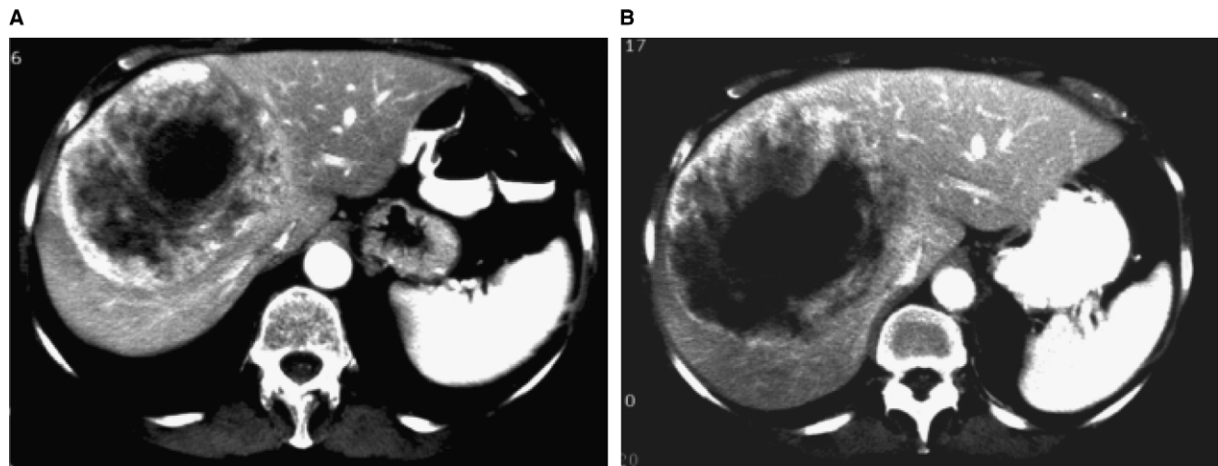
CT scan of liver metastasis from gastro-intestinal stromal tumour (GIST) in a 69-year-old woman treated with SU006668 for 28 weeks at 200 mg/m². (A) Baseline. (B) Post-treatment: Increased necrosis of the liver metastases with decrease of the peripheral hypervascular rim.
